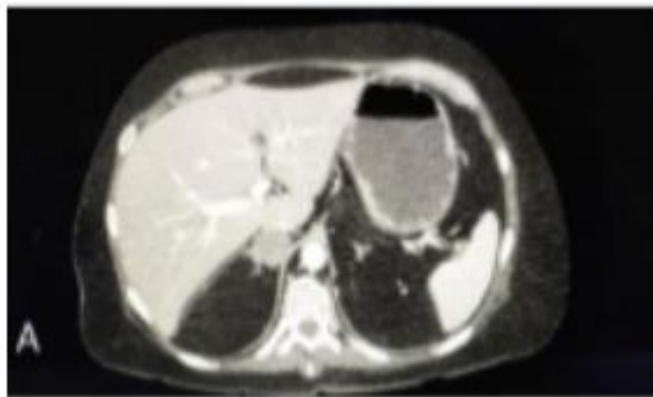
(A) Abdominal computed tomography (CT) scan showing a right adrenal adenoma (B) Thoracic CT scan with diffuse fibrosis and ground glass alterations in both lungs
